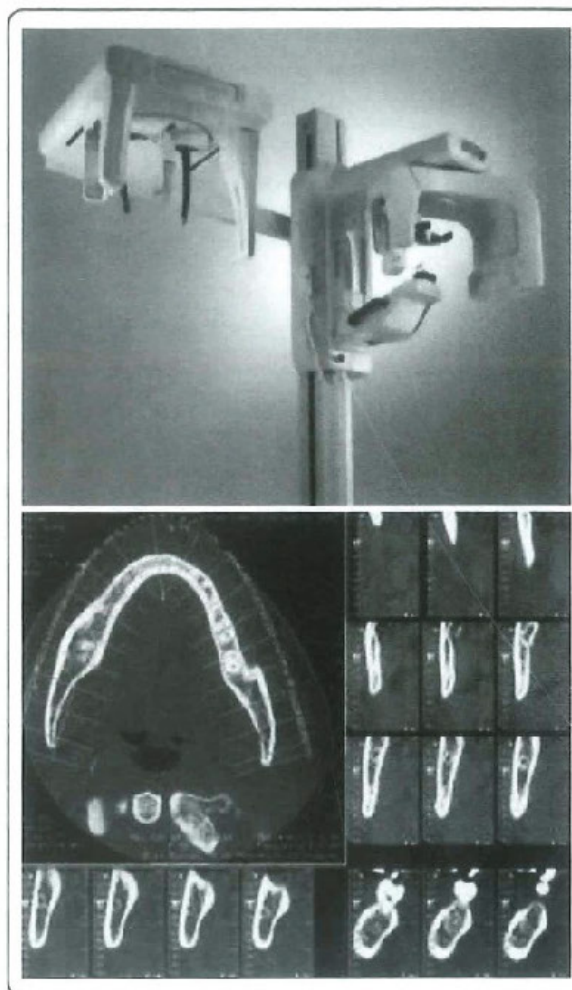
Dental CT machine and a dental CT scan image
